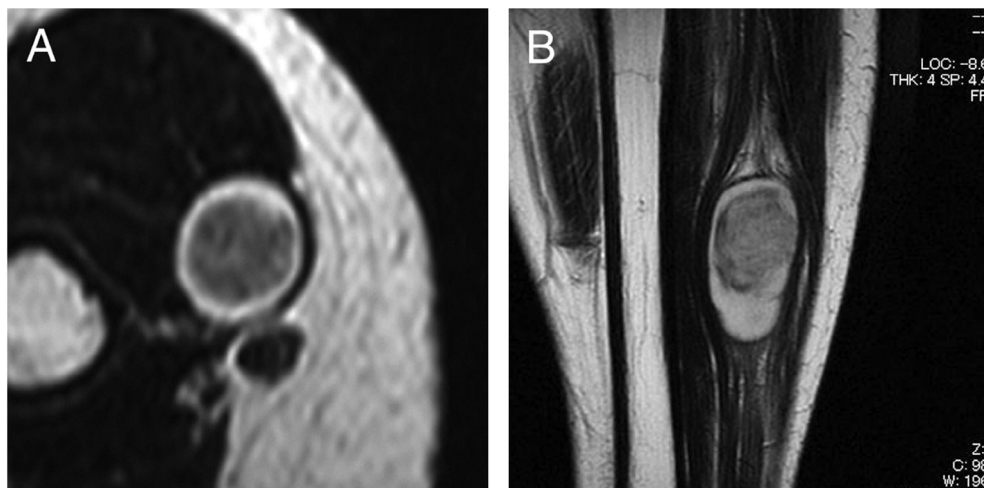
Target sign and split fat sign. A. Schwannoma arising in the thigh showing the target sign (T2-weighted MRI, sagittal view). Target sign consists of a central low-to-intermediate signal intensity with a peripheral ring of high signal intensity. B. Schwannoma arising in the leg showing the split-fat sign (T2-weighted MRI, sagittal view). The split-fat sign is characterized by a rim of fat around the tumor. The presence of a target sign on MRI indicates a neurogenic neoplasm, whereas a split-fat sign indicates a tumor in the intermuscular space [3].
